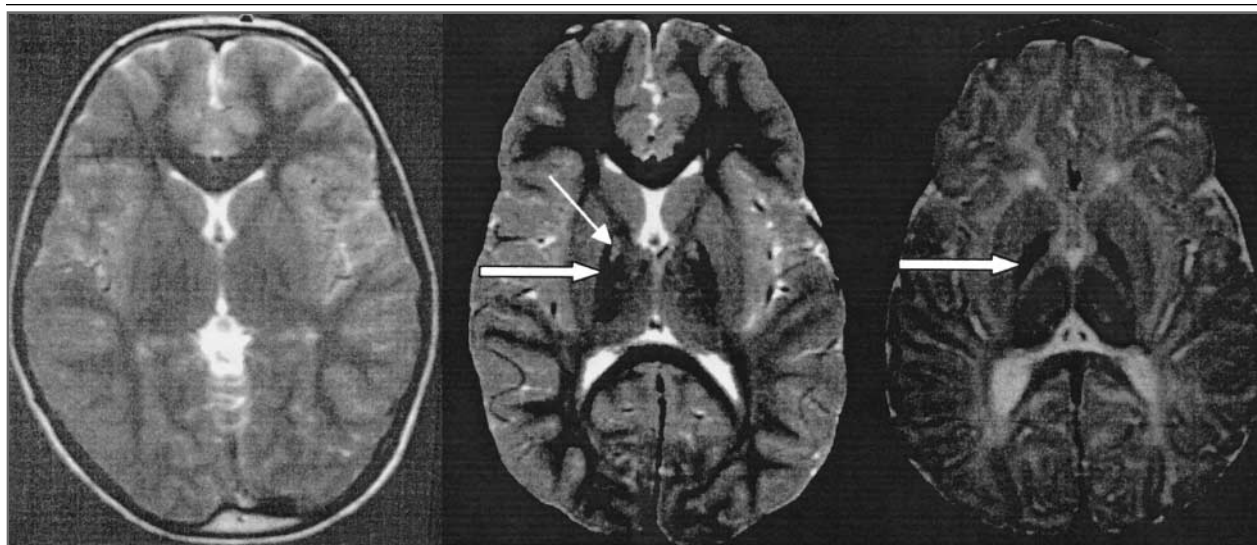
Patterns on T₂-Weighted Brain Magnetic Resonance Imaging.
